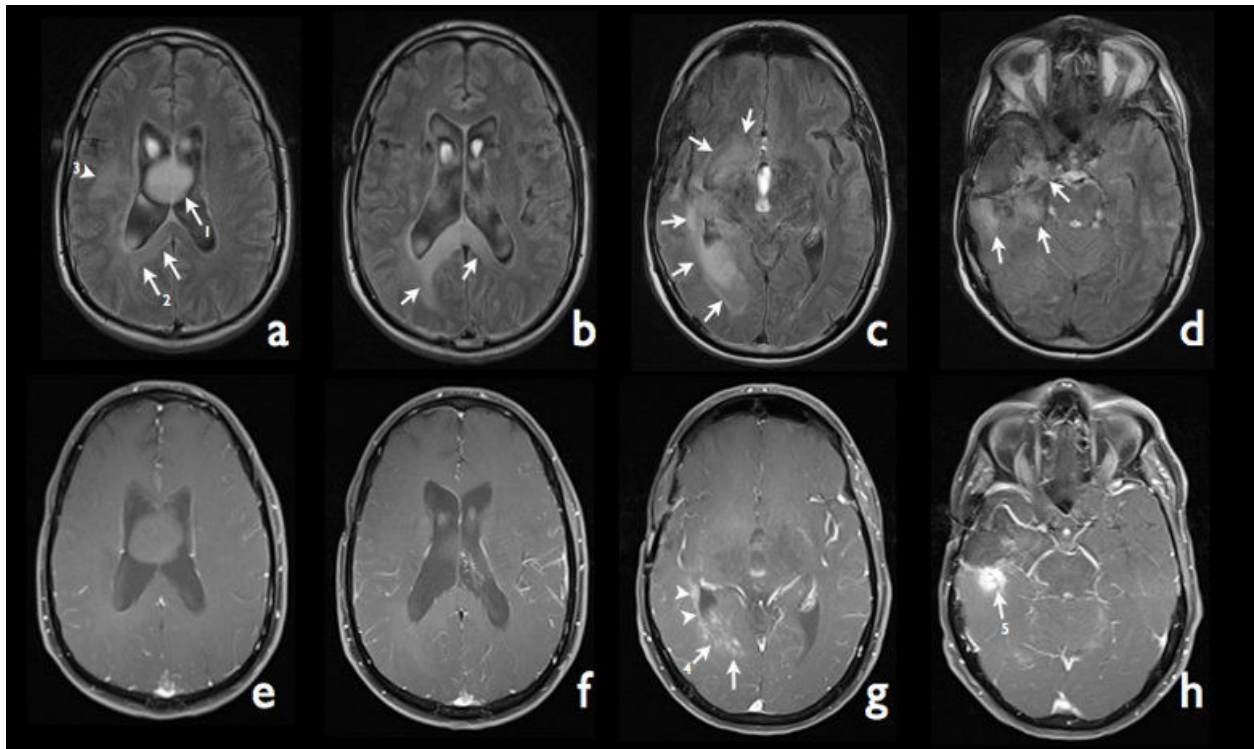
Five more months after discovery of the abnormalities in the corpus callosum, FLAIR images (a, b, c, d) depicted significant enlargement of the lesions in the corpus callosum (arrows in a) with extension to the left aspect of the genu and right occipital periventricular white matter (arrows in b). Also noted was a newly developed nonenhancing lesion in the right middle frontal white matter (arrowhead in a). Around the surgical cavity showed a thick rim of irregular increased signal involving the orbitofrontal lobe, hippocampus, temporal lobe and occipital lobe (arrows in c and d). Post-contrast T1WI (e, f, g, h) delineated a patchy nodular enhancement (arrows in g) around the occipital horn of the right lateral ventricle with subependymal tumor extension (arrowheads in g) and a solid enhancing nodule (arrow in h) in the posterior margin of the surgical cavity. The rest of the lesions were not enhancing. Stereotactic biopsy was performed in five locations (denoted with numbers 1 to 5).
